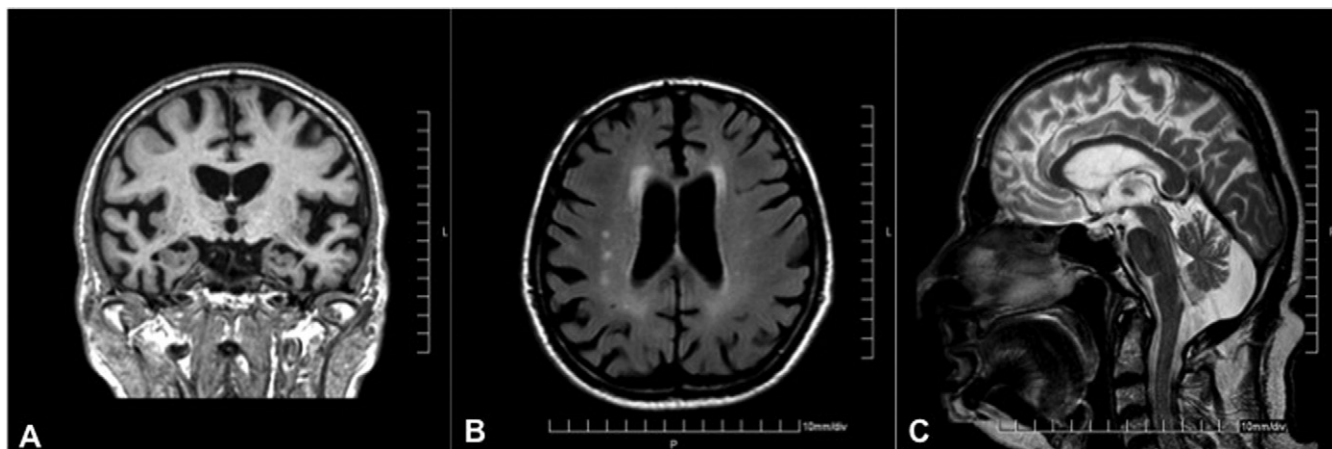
Brain magnetic resonance imaging for proband (patient IV.4). (A) Coronal T1 weighted image demonstrates right hippocampal and cerebellocortical atrophy. (B) Axial Fluid attenuated inversion recovery (FLAIR) magnetic resonance reveals confluent white matter hyperintensities adjacent to the anterior and posterior horns of the lateral ventricle and single lesions in the right frontal white matter. (C) In sagittal T2 weighted images corpus callosum seems normal.
